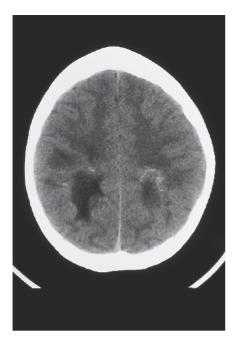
CT scan of the brain of HM, a boy with ALD. There was extensive leukodystrophy and calcification around the lucent area of demyelination.
